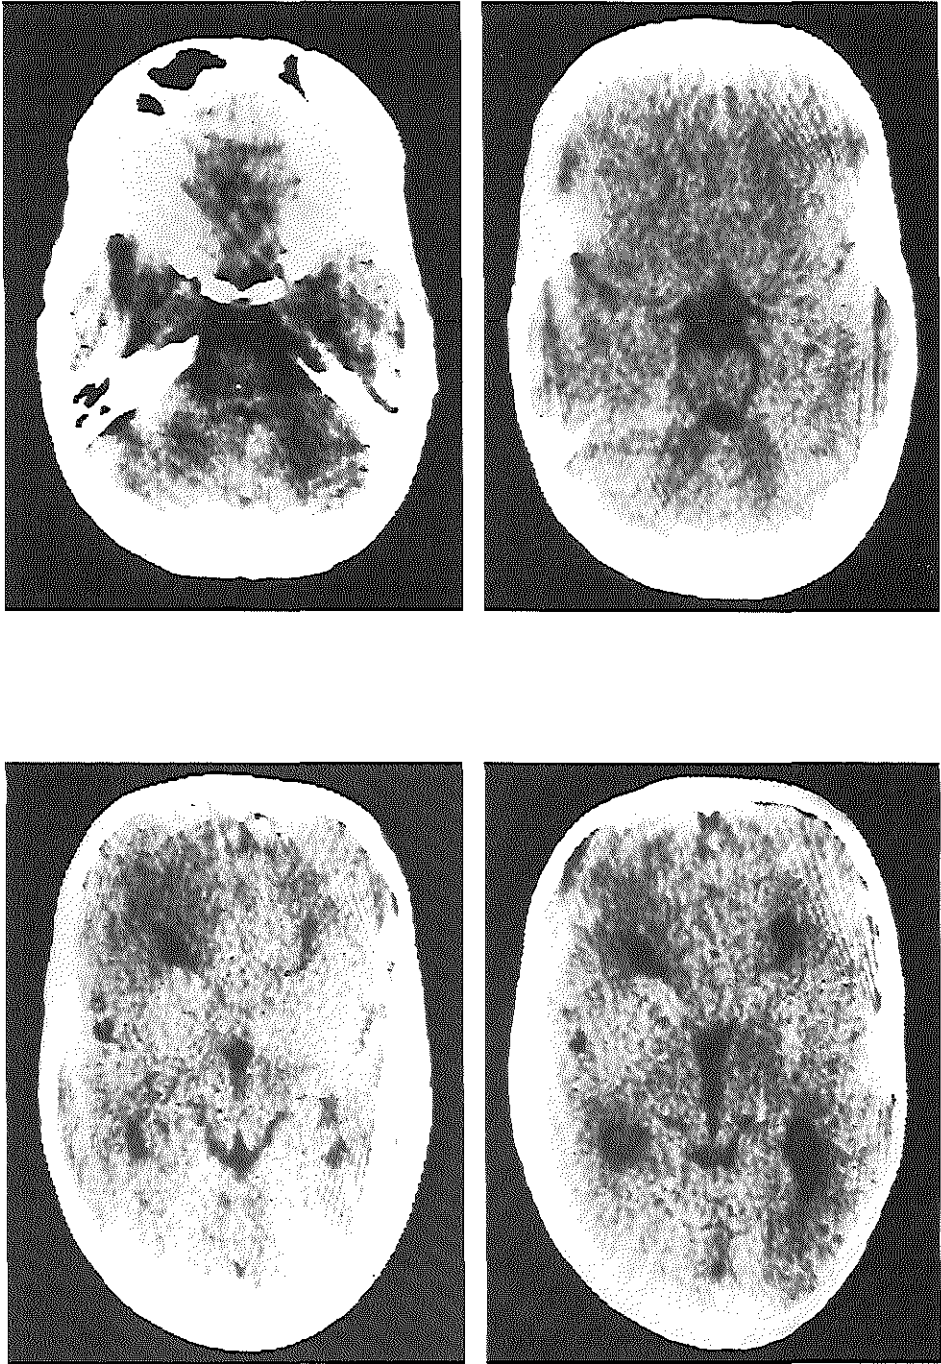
CT scan of a child with agenesis of the corpus callosum.
